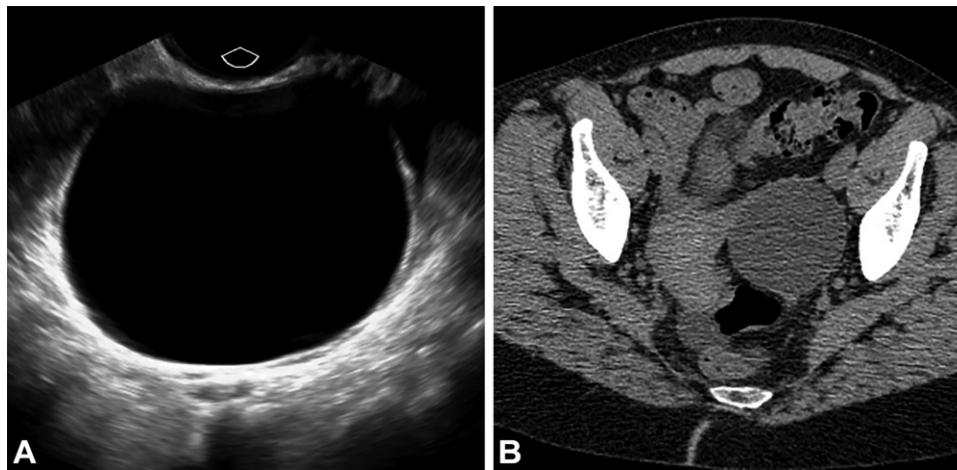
Simple cyst in a postmenopausal woman (O-RADS 2). (A) Gray-scale US image shows a simple 6-cm cyst. This simple cyst may be a slow-growing benign neoplasm or a paraovarian cyst. Based on its size, the O-RADS recommendation would be a 1-year follow-up. (B) Axial CT image obtained 2 years earlier shows a homogeneous hypoattenuating (2 HU) simple-appearing cyst of the same size, indicating benignity, and thus further US follow-up is unnecessary.
